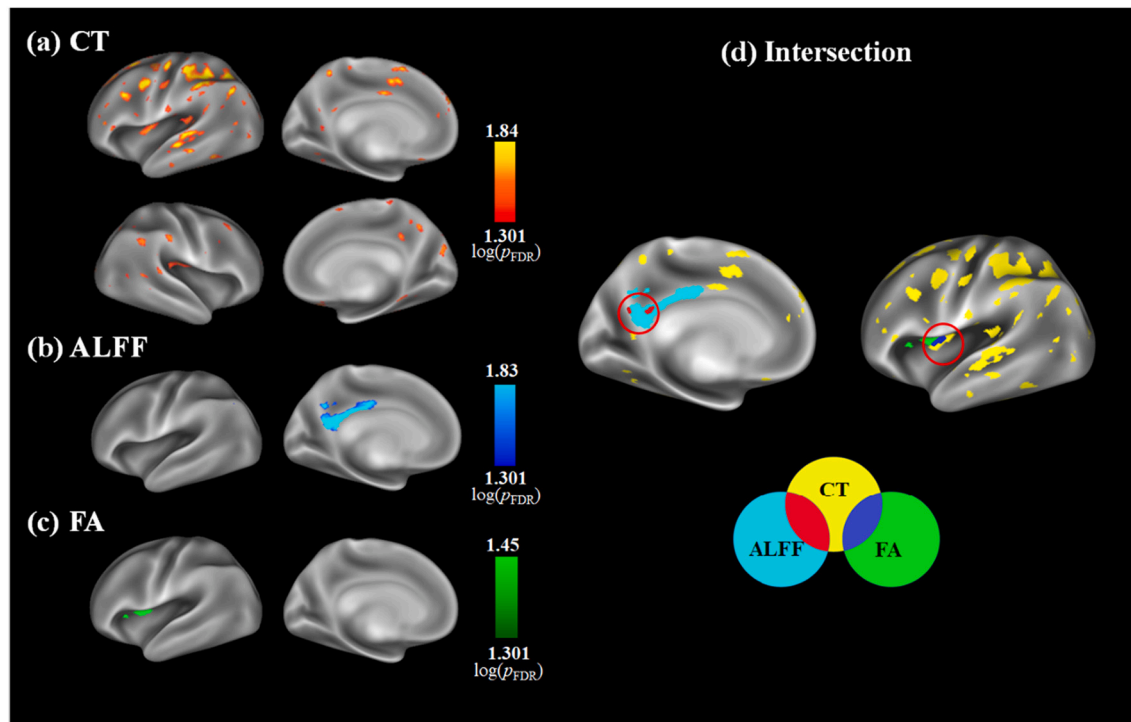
Surface-based analysis of the abnormal cortical areas in multimodal imaging measures (CT, cortical thickness; FA, fractional anisotropy; ALFF, amplitude of frequency fluctuations) and their overlapping areas. (a) CT, (b) FA, and (c) ALFF. On the fs_LR 32 k surface, the BD-II patients showed lower values in imaging measures (CT, FA, and ALFF) than those in the controls. The results are displayed with a threshold at $p_{FDR} < 0.05$ or $(-\lg(p_{FDR}) > 1.301)$. Each color bar represents FDR-corrected $-\lg(p)$ values for each measure. (d) Intersection areas between CT and FA as well as between CT and ALFF. The BD-II patients showed significantly lower CT and FA in the left AI (blue) and lower CT and ALFF in the left PCC (red) than the healthy controls. (For interpretation of the references to color in this figure legend, the reader is referred to the web version of this article.)
